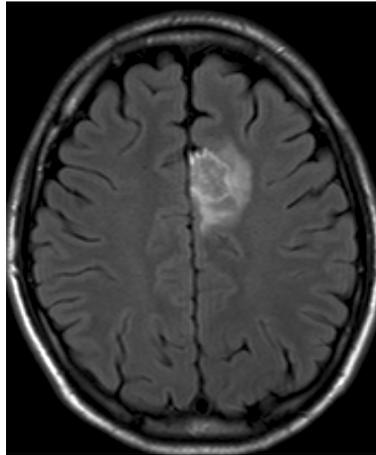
23-year-old male, presenting with epilepsy. The MRI showed an intracerebral lesion. A PET-CT demonstrated mediastinal lymph node and pulmonary involvement compatible with sarcoidosis. The diagnosis of sarcoidosis was confirmed with endobronchial ultrasound fine-needle aspiration (EBUS-FNA).
